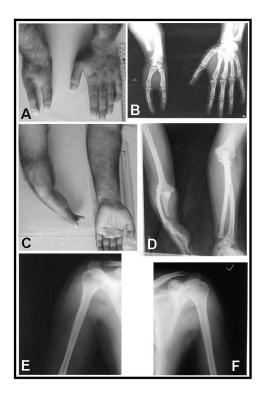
Photographs and radiographs of upper limbs of subject B
